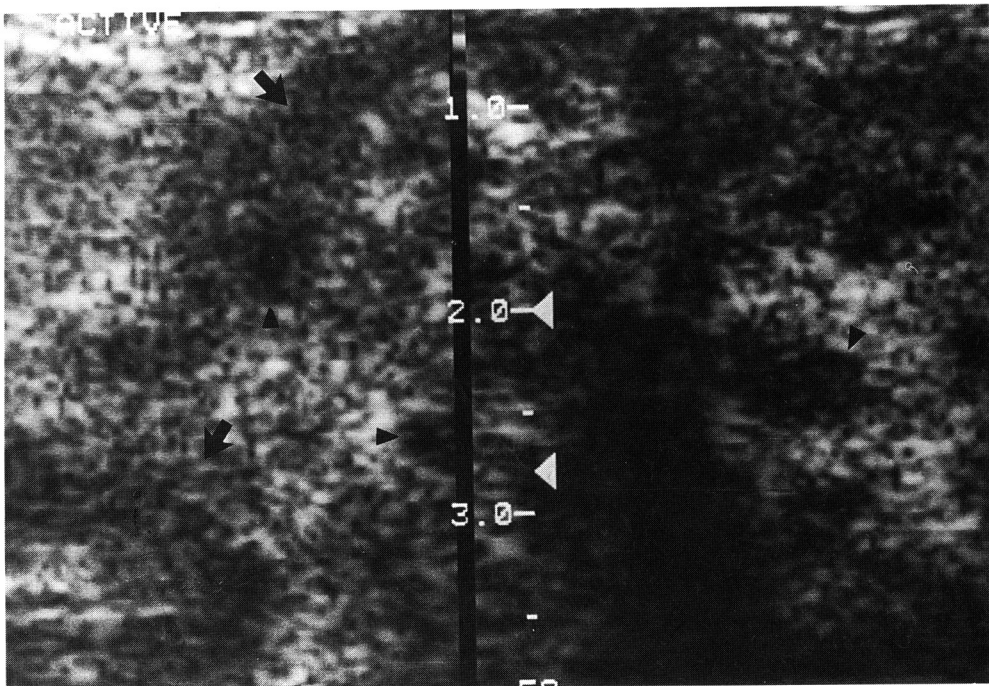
Sonography of the left breast mass shows a diffuse heterogenous echoic mass. Multiple low (arrows) and medium (arrowheads) level echoes are intermingled within the mass.
